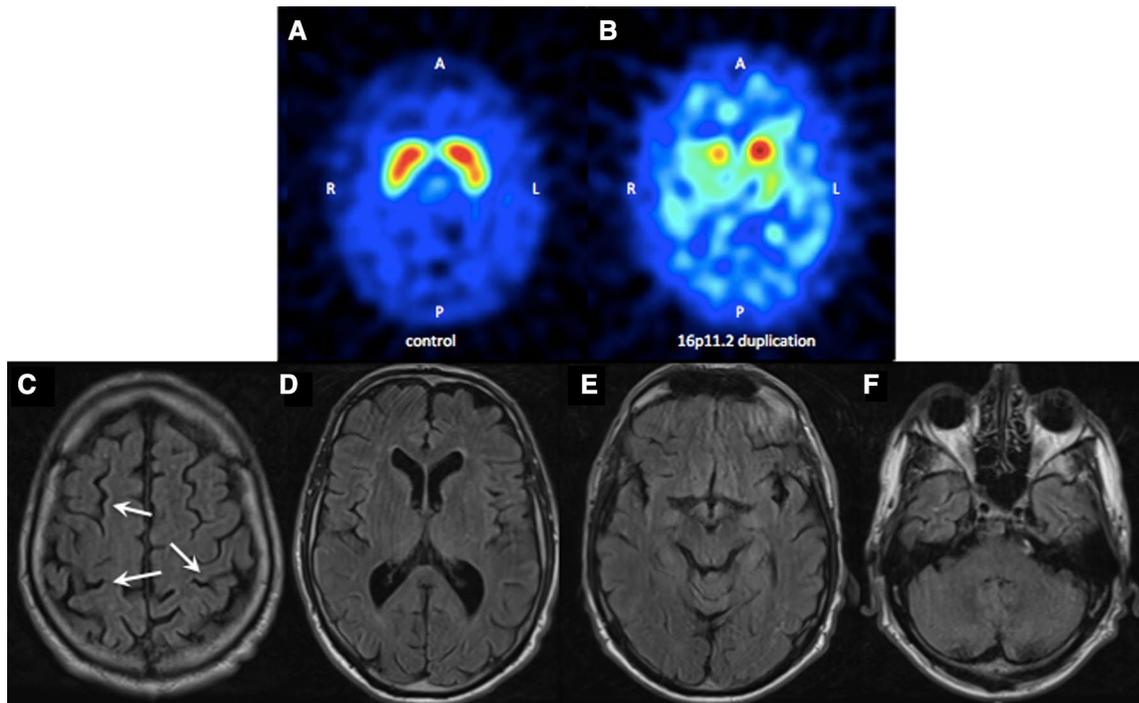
123I-Ioflupane-SPECT (FP-CIT; DaTSCAN™) and MRI of the patient with 16p11.2 duplication syndrome: severely reduced dopamine transporter activity of the striatum, particularly pronounced on the right side (b) compared to an age-matched, healthy individual
